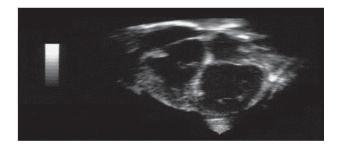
Ultrasound image of a beating heart (FONG *et al* 2011)
